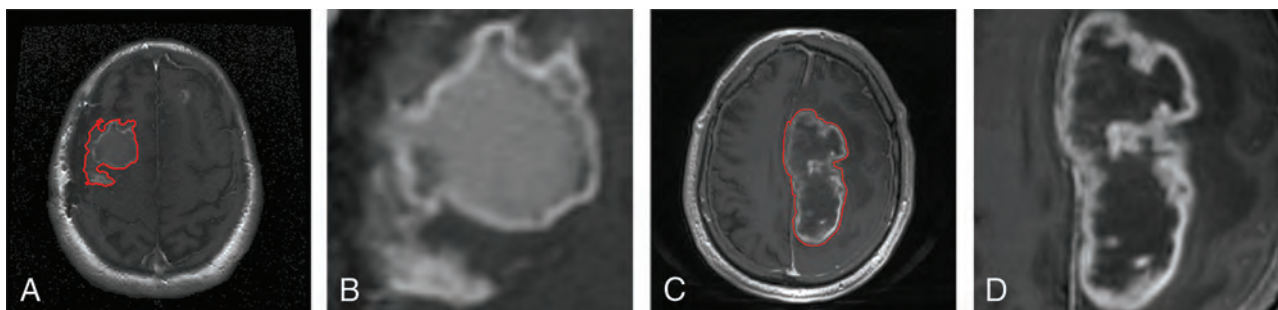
Example of contrast-enhanced T1-weighted MR images of longer term survivors (A and B) with an overall survival of 1405 days and shorter term survivors (C and D) with an overall survival of 447 days. A and C, Contrast-enhanced T1-weighted MR images with tumor contours in red. B and D, Tumor patches segmented from A and C, respectively.
